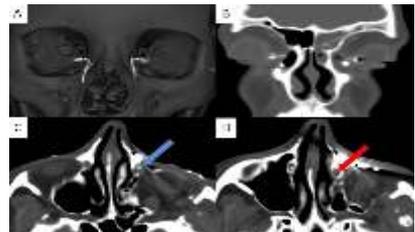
CT-DCG done at a radiology service. (A) Bilaterally patent lacrimal system in a patient with normal nasolacrimal system. (B) Bilateral congenital lacrimal fistula (not evident on the image) with patent NLD in the right eye and distal NLDO in the left eye. (C) Proximal and (D) distal axial cuts in a patient with left-sided repaired orbital floor fracture. Right NLD is patent, while left nasolacrimal system shows dye filling the lacrimal sac (blue arrow) and no dye in the distal NLD (red arrow) suggestive of NLDO.
